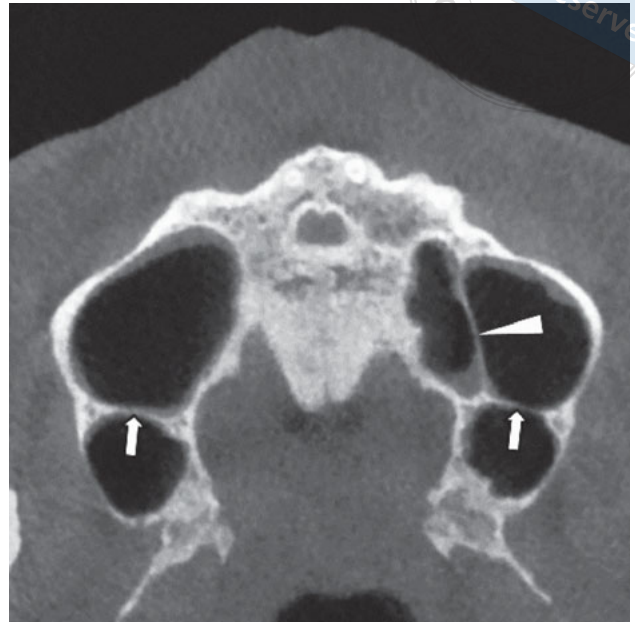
Two buccopalatal septa (\uparrow) and one sagittal septum (\blacktriangle) were observed on the axial view of the CBCT scan.
